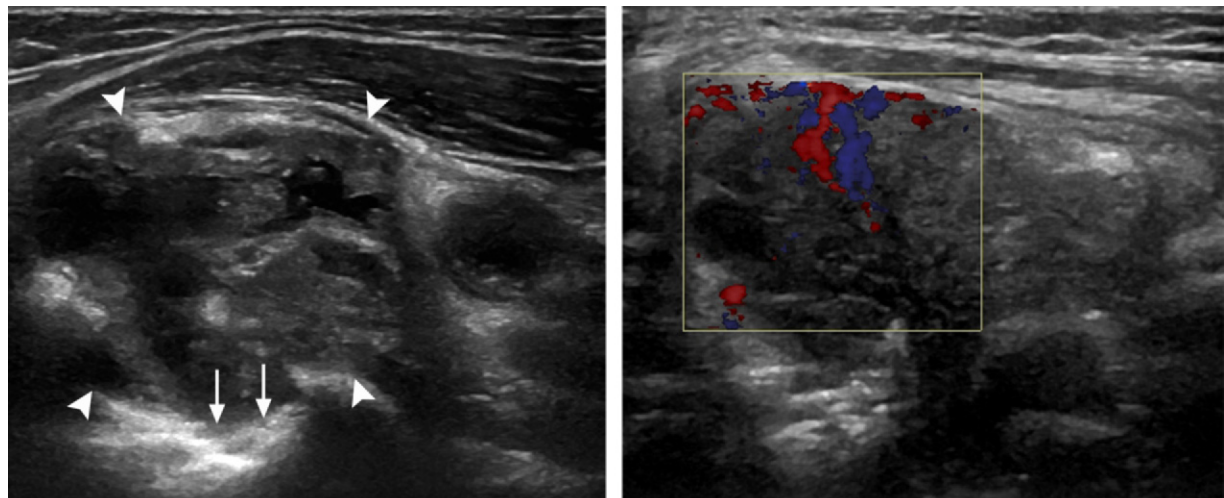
Rheumatoid arthritis in a 61-year-old man with active synovitis. Transverse gray-scale (a) and color Doppler (b) US images of the left anterior elbow joint show marked pannus formation (arrowheads in a) with moderate hyperemia. Subjacent to the pannus are numerous osseous erosions (arrows in a).
